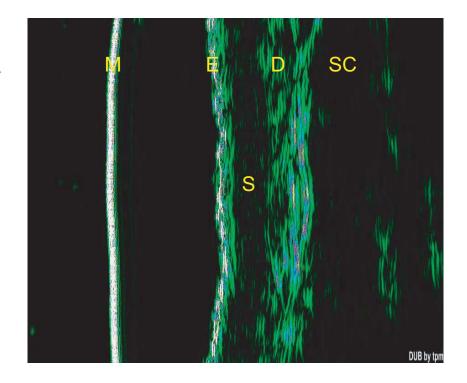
Typical ultrasound image of subepidermal lowechogenic band (SLEB) (S) located immediately below the epidermal entrance echo (E) Unfortunately, no protocols for skin mesotherapy exist, and different treatment modalities have been suggested.⁹ The most frequently used agent is hyaluronic acid (HA) in a very fluid formulation. Vitamins and oligoelements may be added to HA.^{8,9}
